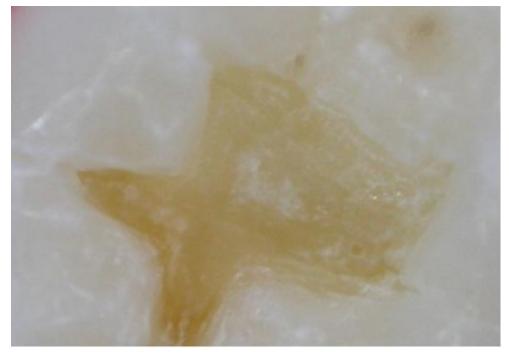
Carious cavity prepared by ultrasound method
